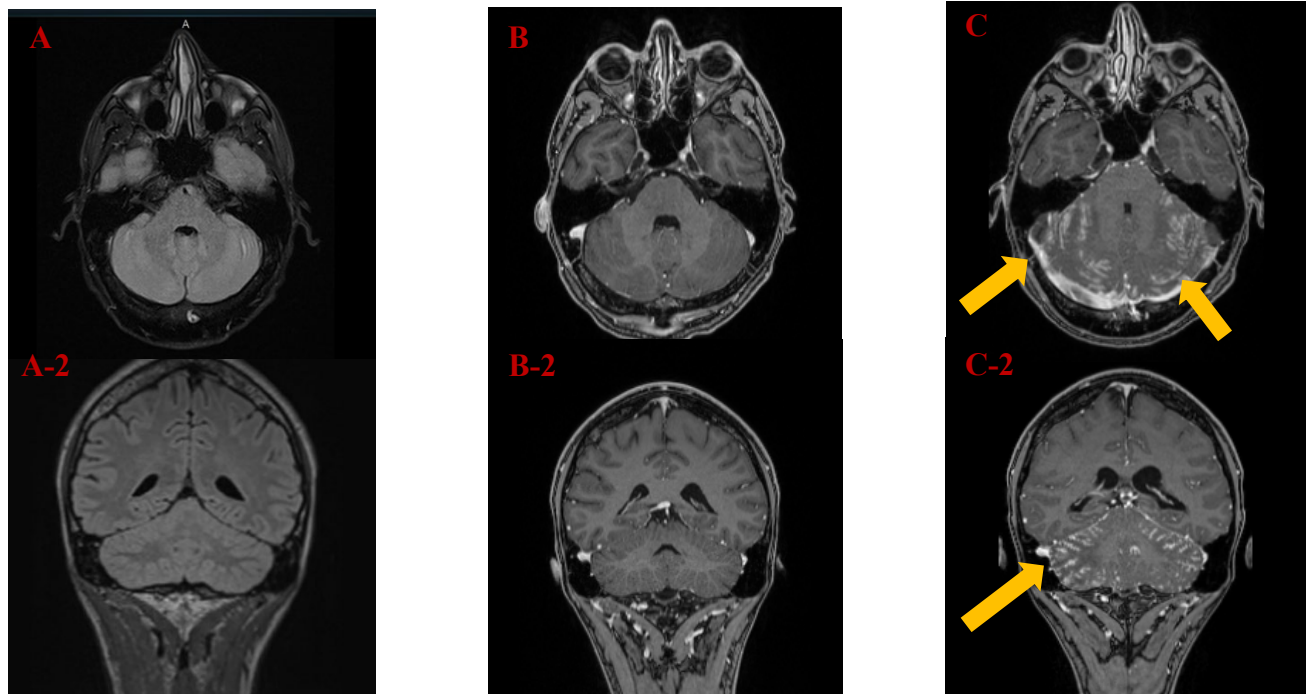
MRI FLAIR Imaging. (A & A2) Initial admission (1/27/2021) with no evidence of acute or significant intracranial abnormality. No abnormal enhancement is noted in the brain. (B & B2) Continued normal MRI during follow up period (5/03/2021). (C & C-2) Second admission (11/16/2021) with increased FLAIR hyperintensity predominantly involving cerebellar hemispheres as well as leptomeningeal enhancement. Examples of radiological findings are indicated with yellow arrows.
